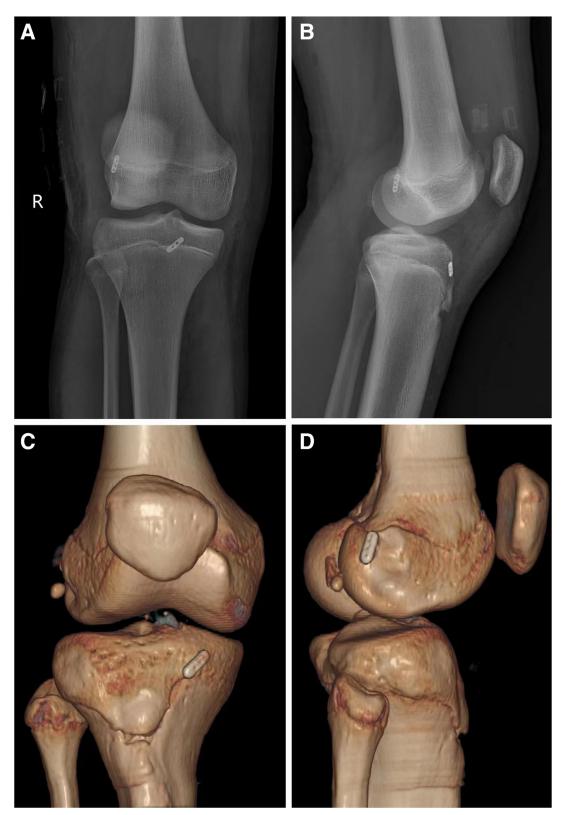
(A) Orthostatic radiography of the right knee with physeal-sparing, all-inside ACL reconstruction and fixation with TightRope RT suture buttons. (B) Right lateral radiography of the right knee with physeal-sparing, all-inside ACL reconstruction and fixation with TightRope RT suture buttons. (C) Orthopantomographic CT plain film of the right knee with physeal-sparing, all-inside ACL reconstruction and fixation with TightRope RT suture buttons. (D) Right lateral CT plain film of the right knee with physeal-sparing, all-inside ACL reconstruction and fixation with TightRope RT suture buttons. (D) Right lateral CT plain film of the right knee with physeal-sparing, all-inside ACL reconstruction and fixation with TightRope RT suture buttons. (ACL, anterior cruciate ligament; CT, computed tomography.)
